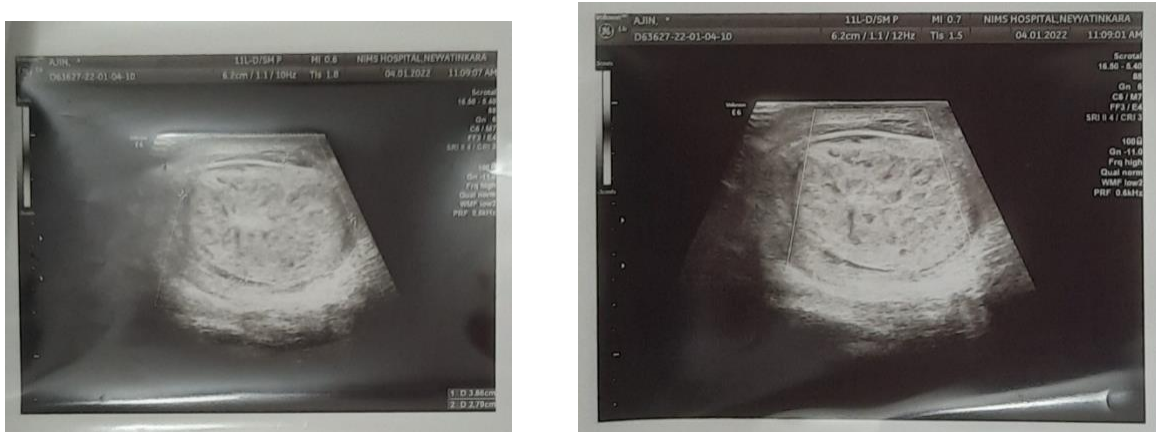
doppler study of scrotum featuring left torsion testis with internal hypoechoic areas.
